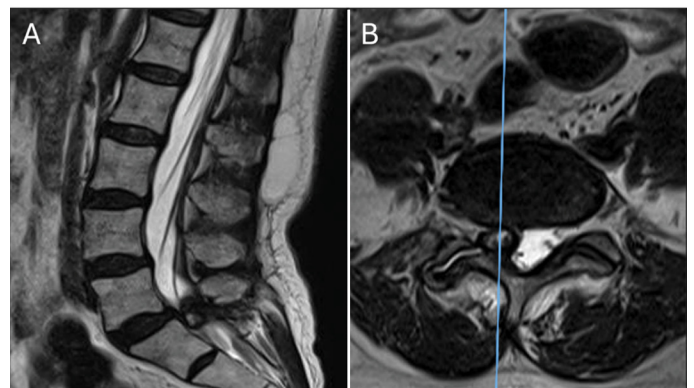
Magnetic resonance imaging in sagittal (A) and axial (B) cuts showed a lesion that projected in the right lateral recess of L5/S1, compressing the proximal segment of the root of S1.
